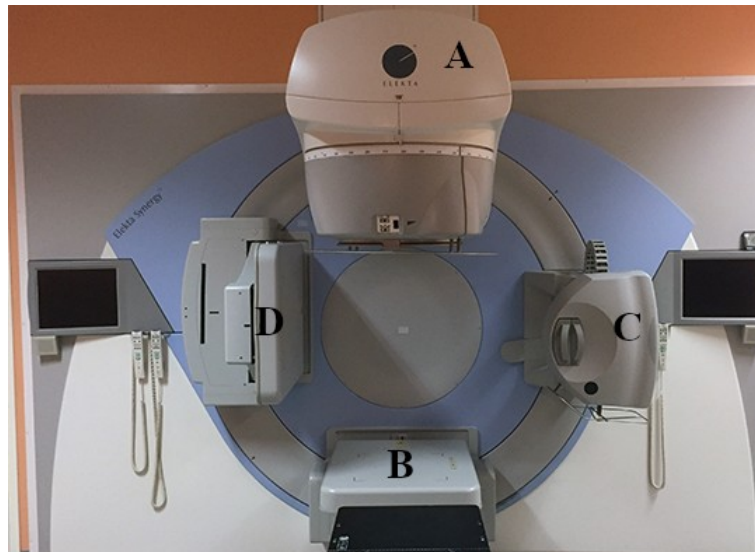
Typical assembly of a modern linear accelerator with cone beam CT: A – MV-irradiation source, b- – digital MV-image converter to check patient position with the treatment beam, C – kV-x-ray generator, D – kV-image converter to acquire CT-data.
